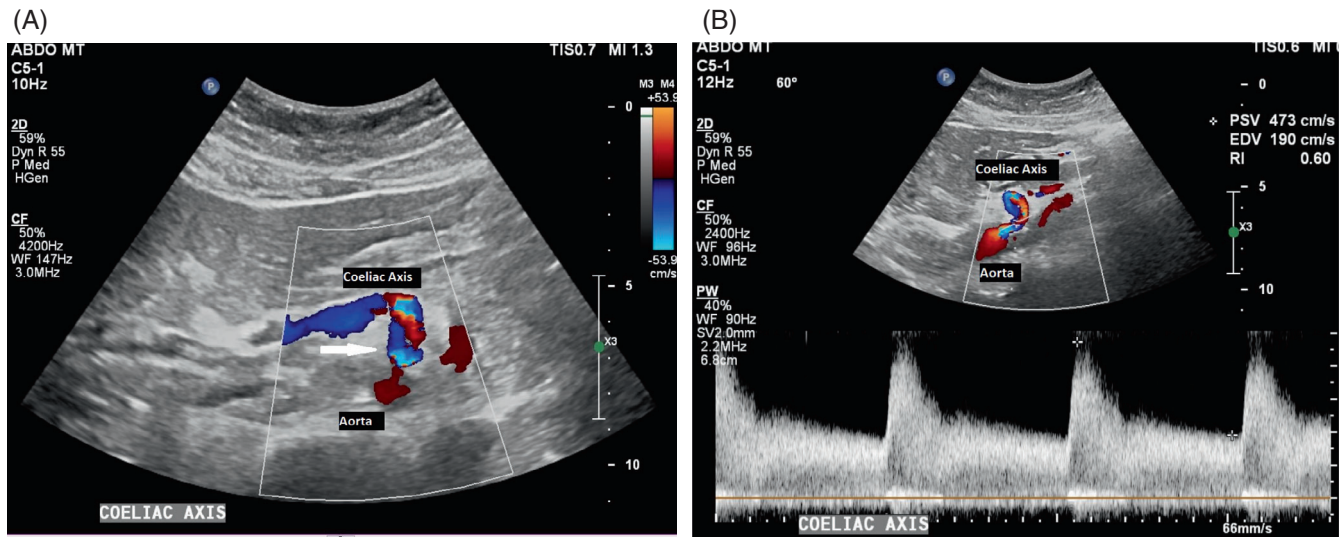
(A) Colour Doppler of the Coeliac Axis Origin. (B) Spectral Doppler trace of the Coeliac Axis Origin.
